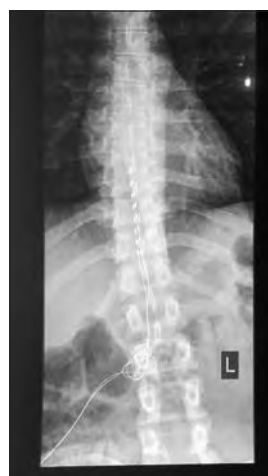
X-ray of thoracolumbar region showing the Spinal Cord Stimulator leads at T9-T11
